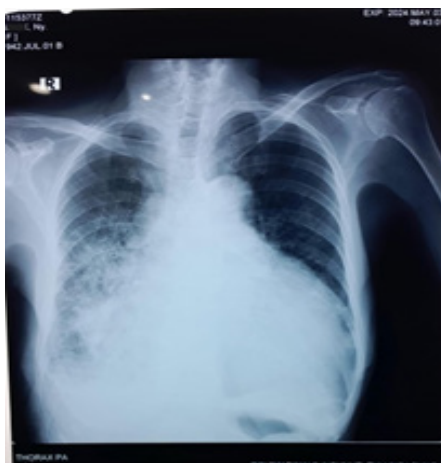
Chest X-ray showing Infiltrate and Cardiomegaly
